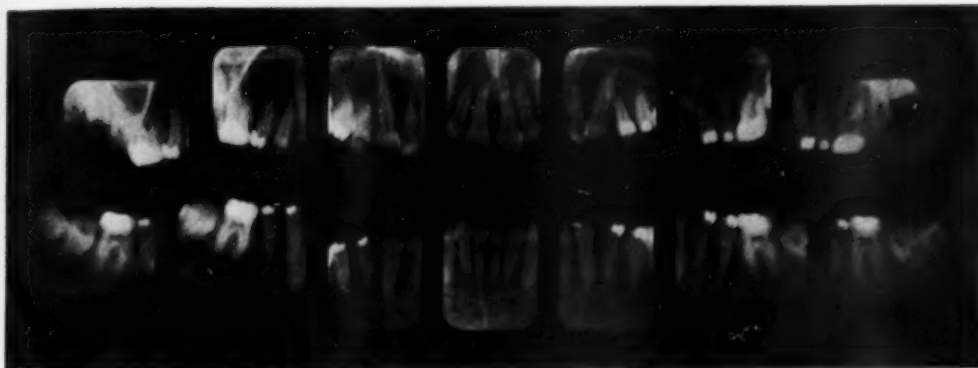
Hypoparathyroidism. Roentgenogram showing hypoplasia of the enamel of all premolars and the unerupted second and third molars; all these are teeth in which the pattern of enamel formation is established at two years of age and later. Other teeth are unaffected. The defects of enamel suggest that the disease had its onset at two to three years of age. (Reproduced, with permission, from Stafne, E. C.: *Dental Roentgenologic Aspects of Systemic Disease*. J. Am. Dent. A. 40: 265-283, March 1950.)
